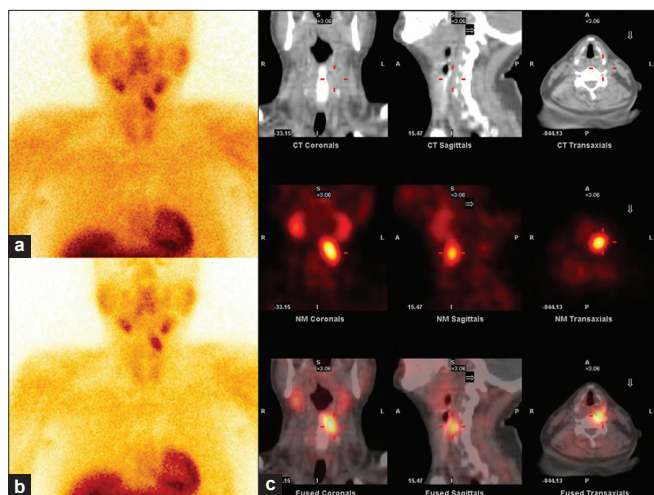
A 49-year-old male presented with hypercalcemia and mildly elevated PTH. USG of the neck did not reveal any parathyroid adenoma. (a) Early images of Tc99m sestamibi scan show homogenous tracer uptake in the both lobes of the thyroid gland. A focus of intense area of tracer uptake is noted in the cervical region superior to the left lobe of the thyroid gland. (b) Delayed images show retention of the tracer in the focus with wash out from thyroid gland. (c) SPECT/CT images show focal tracer uptake in the prevertebral region opposite to the body of C-6 vertebra
